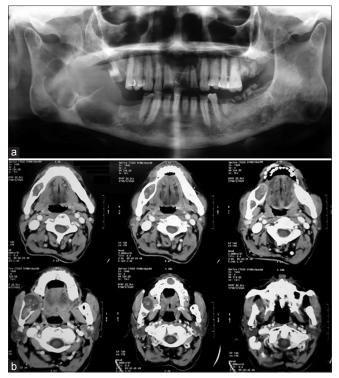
(a) Orthopantomogram showing multiple radiolucencies. (b) Computerized tomography showing location and extent of the lesions
